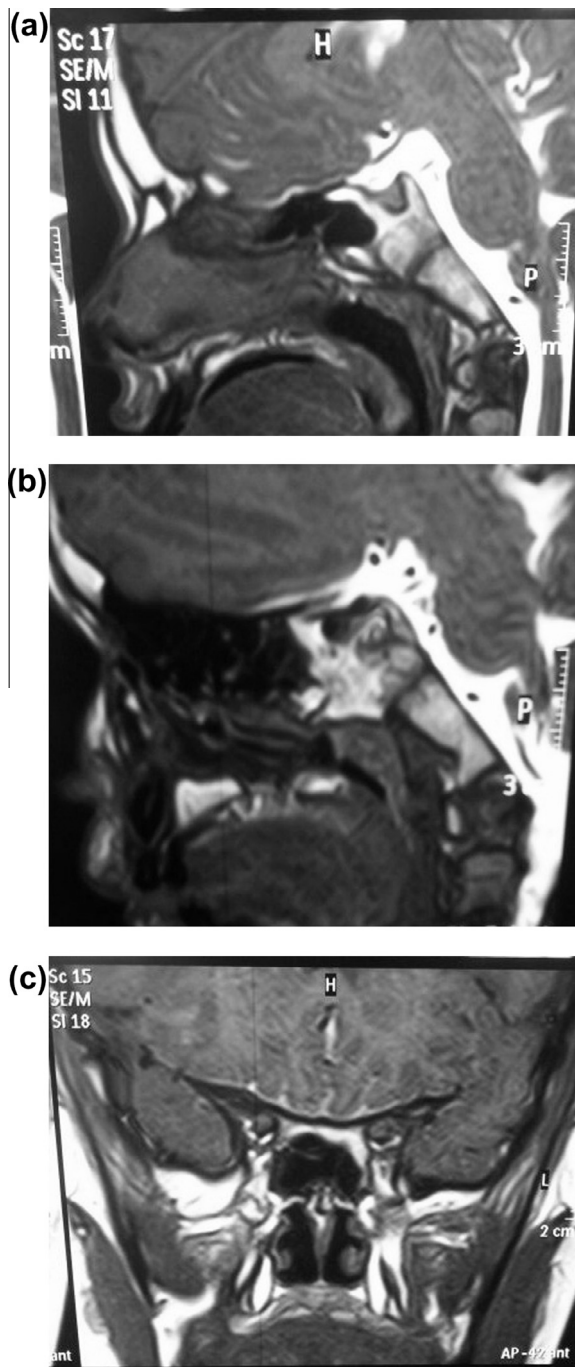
CSF rhinorrhea in a 44-year-old female following traumatic insult. (a, b) Mid- and para-sagittal T1-weighted contrast enhanced MR cisternogram reveals focal contrast leak into the sphenoid sinus through a small defect detected and repaired on endoscopy. (c) Coronal T1-weighted contrast enhanced MR cisternogram shows partial opacification of the sphenoid sinus by contrast leak from the subarachnoid space through the bony defect.
